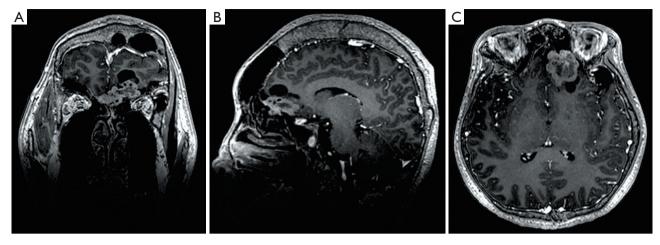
The coronal (A), sagittal (B), and axial (C) planes of pre-operative brain and pituitary MRI with GBCAs. It showing a small nodular abnormal signal on the left side of the pituitary, approximately 7 mm in diameter, and a cystic-solid mixed soft tissue mass in the left sphenoid sinus and anterior cranial fossa, with a maximum diameter of approximately 3 cm. MRI, magnetic resonance imaging; GBCAs, gadolinium-based contrast agents.
